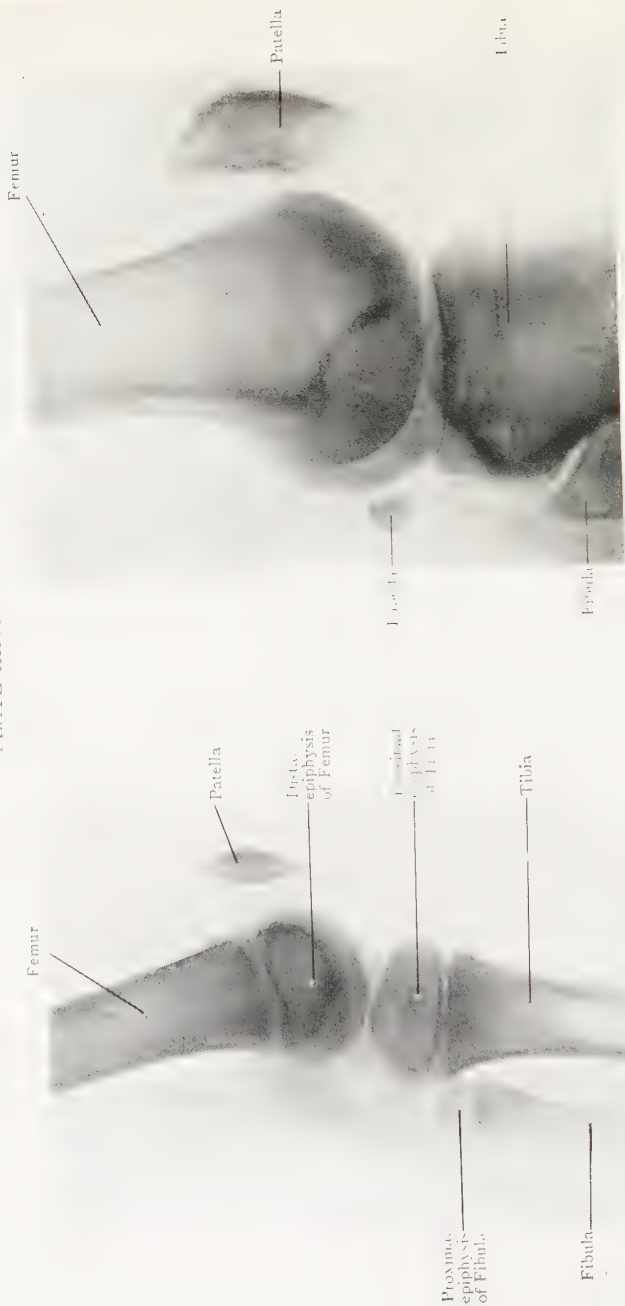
Lateral Radiograph of Knee of boy aged 7.
